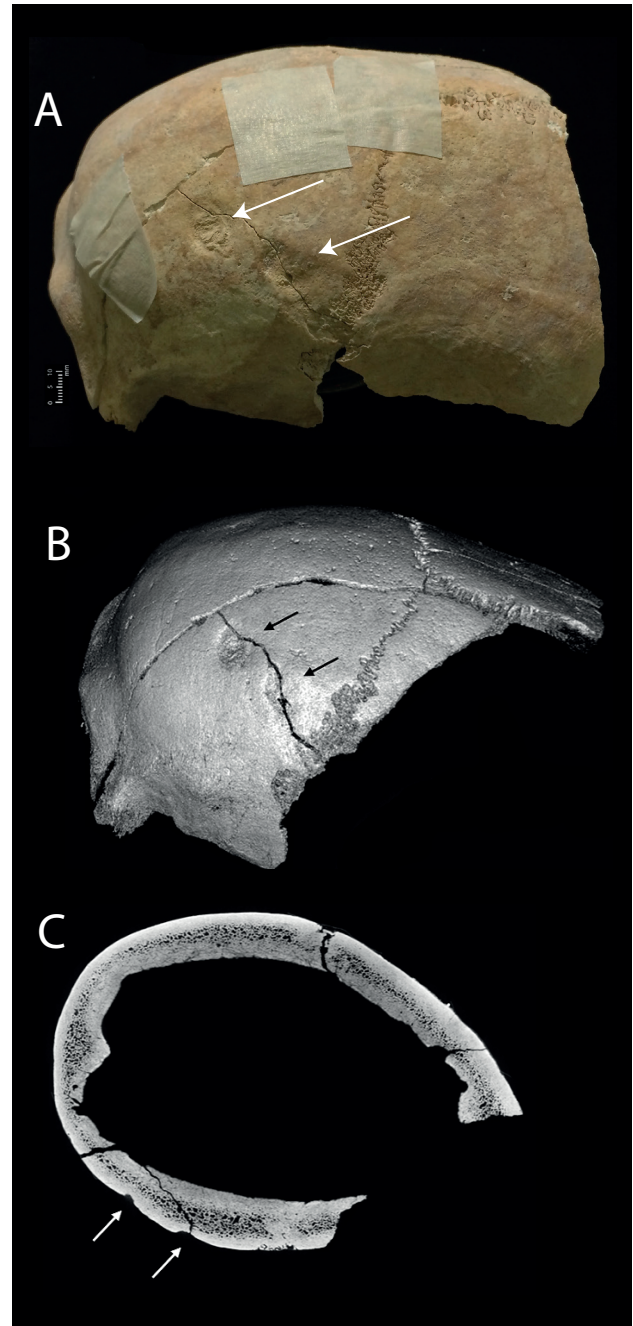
a) Fragmentary remains of adult possible male cranium (FB0006) from Context (1238) of the Circle, featuring two focal depressions on the ectocranial surface of the left supero-lateral aspect of the frontal squama; b) 3D render of fragmentary remains; c) cross-section from CT data of fragmentary remains, showing that both focal depressions do not extend deeper than the outer table. Scale bar: 1 cm (photograph only). (Photos Ronika. K. Power; radiological images captured by L. Buck, Cambridge Biotomography Centre; processed by J. Magnussen & M. Pardey, Macquarie Medical Imaging).
